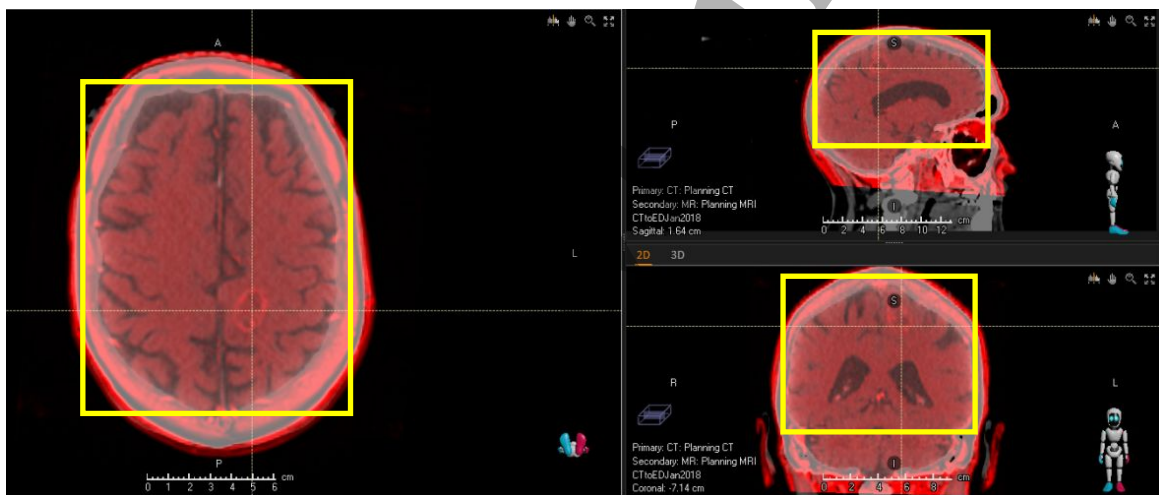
Local RIR for a patient with a glioblastoma. Grey overlay images are CT and red overlay images are MRI. The recommended guiding ROI used for local registration is shown in yellow.
